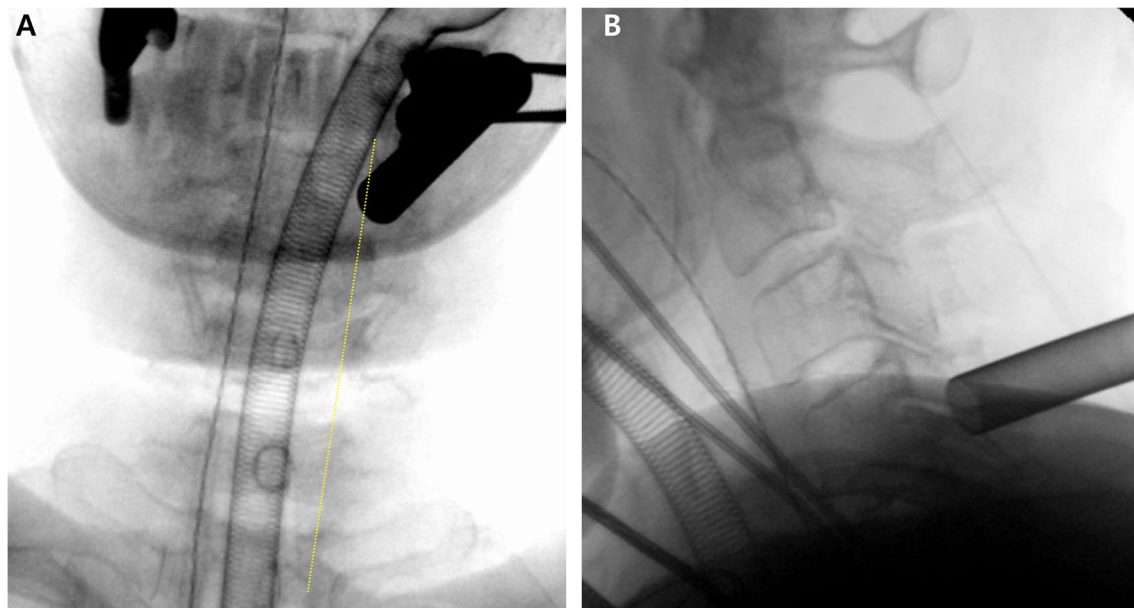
Fluoroscopic images during surgery. A: Anteroposterior (AP) X-ray shows the tip of the working channel is placed on medial pedicle line (yellow dotted line). B: Lateral X-ray shows the approach trajectory
